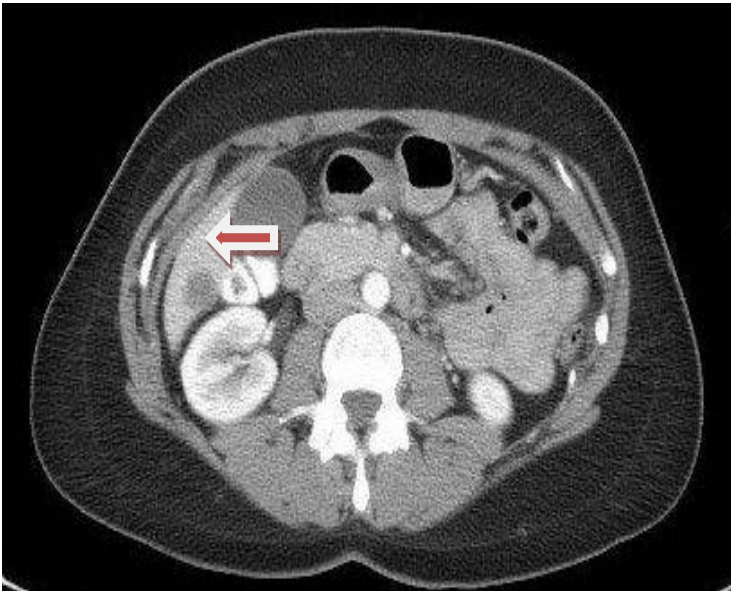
shows FDG PET/CT in a 35-year-old woman who presented with lung and liver metastases. As a baseline (Figure 4A) for a clinical trial, she had CT chest, abdomen, and pelvis with contrast as required by protocol which used RECIST 1.1 criteria to assess response. She also had a PET/CT. After the first 3 months of chemotherapy she was re-imaged (4B) as per protocol and demonstrated complete response in the lung and near complete response in the liver on both CT and PET/CT with a residual small, mildly FDG avid lesion in the posterior right lobe. She therefore qualified for more chemotherapy after which CT was stable by RECIST
